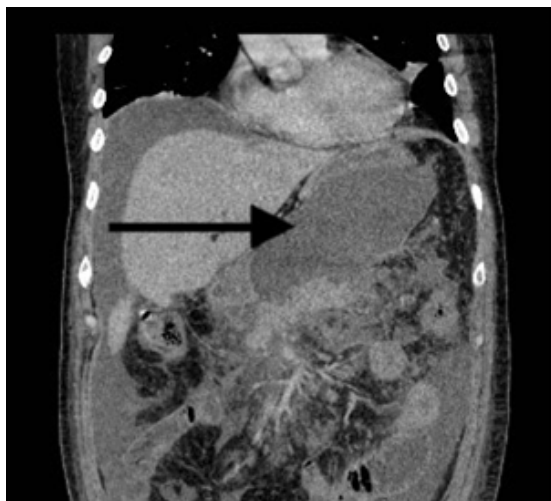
Abdominal CT scan shows pancreatitis and expanding peripancreatic fluid collection.
